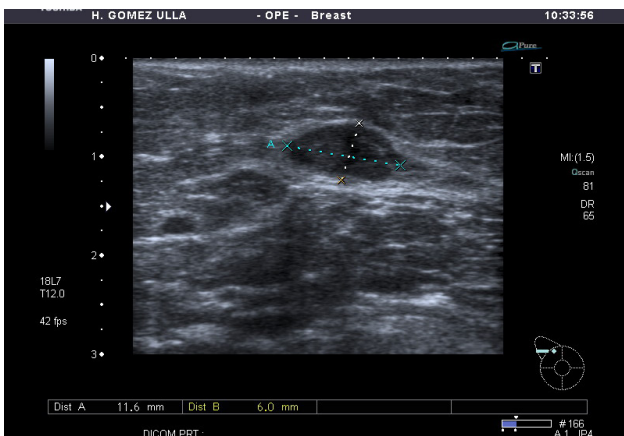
Ultrasound of the right breast showed a regular hypoechoic lesion
